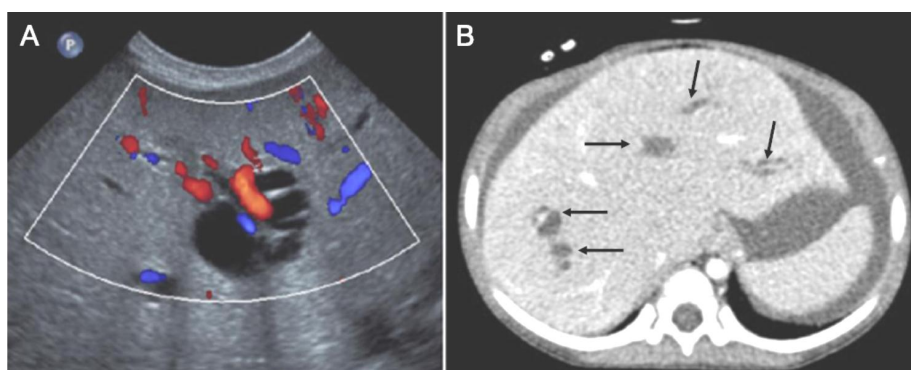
Liver images of patients with *WDR19* mutations. (A) Abdominal Doppler ultrasonography reveals variable dilatation of the intrahepatic bile ducts in patient III-1. Red or blue tubular structures indicate hepatic vessels. (B) Axial computed tomography image of patient IV-1 shows globular enlargement of the liver and dilatation of the intrahepatic bile ducts (arrows), which are consistent with Caroli syndrome. Reprint with permission<sup>22</sup>.
